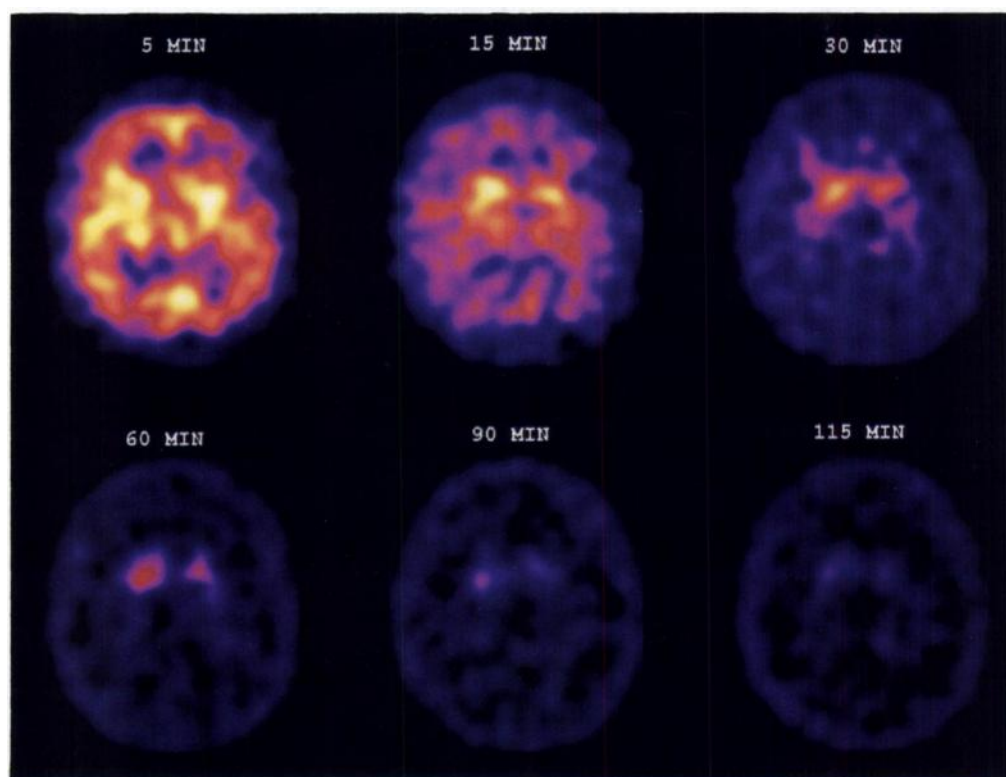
Activity distribution of ^{123}I -IPT after injection of 7.08 mCi (261.96 MBq) into a 49-yr-old man with early Parkinson's disease. Acquisitions were obtained for 5 min each with a triple-headed SPECT camera over 2 hr and reoriented so that the AC-PC line corresponded to the transaxial axis of the data set. Left BG-to-OCC ratios are 1.92, 2.85, 2.28 and 2.67 at 30, 60, 90 and 115 min, respectively. Right BG-to-OCC ratios were 2.27, 3.31, 2.53 and 3.46 at 30, 60, 90 and 115 min, respectively.
